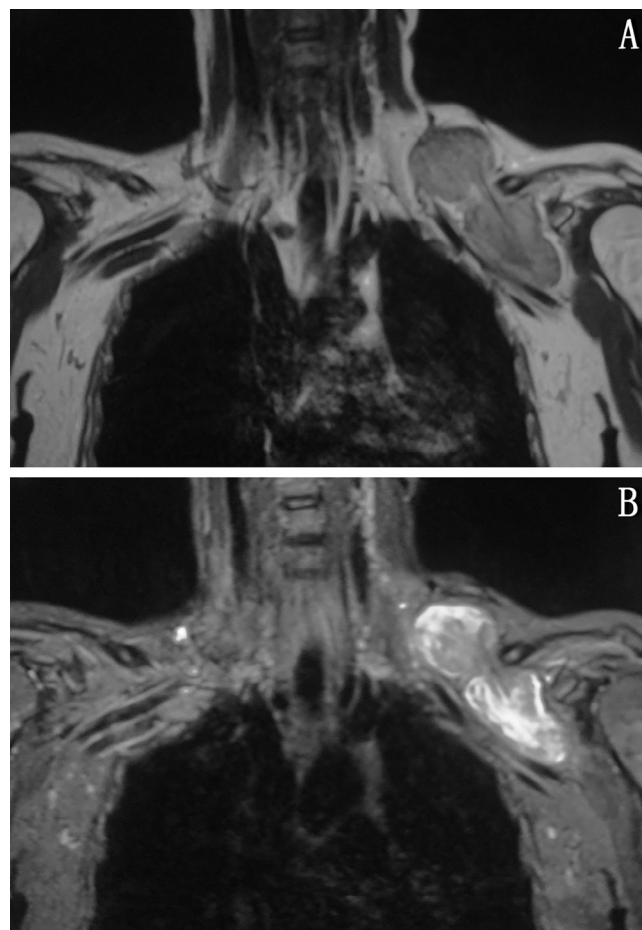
Axial CTA showing subclavian vascular compression caused by the mass. MRI of the neck. (A) Coronal MRI showing the presence of a supraclavicular fossa mass with an inhomogeneous round mass low T1-weighted imaging signal. (B) T2-weighted MRI showing a well-defined mass with a high T2-weighted imaging signal. CTA, computed tomography angiography; MRI, magnetic resonance imaging.
